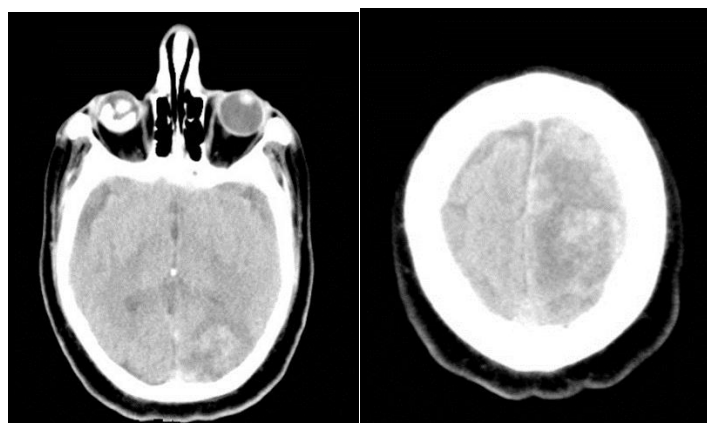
The second noncontrast CT scan of the brain after 24 hours shows hyperdense, hemorrhagic equivalent lesions in the subarachnoid spaces parietally bilaterally, as well as on the left side parietooccipally – an extensive area of increased density with hyperdense foci with an average density of 65 HU centrally and in the upper parietal lobe another one lesion with similar characteristics
